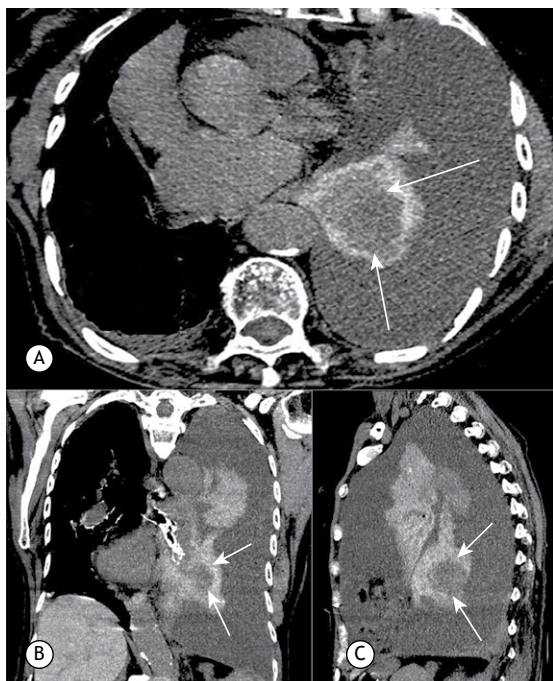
Axial (in A), coronal (in B), and sagittal (in C) chest CT scans showing left pleural effusion and a high-density collapsed lung containing a round hypodense mass (arrows). Note also small right pleural effusion and liver hyperdensity (the liver is denser than the heart).
